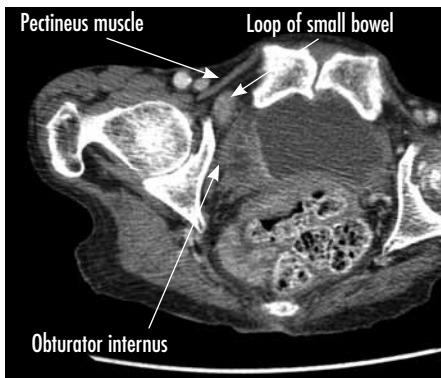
A computed tomography scan showing an obturator hernia on the right side labelled for trapped small bowel, pectineus muscle and obturator internus.
